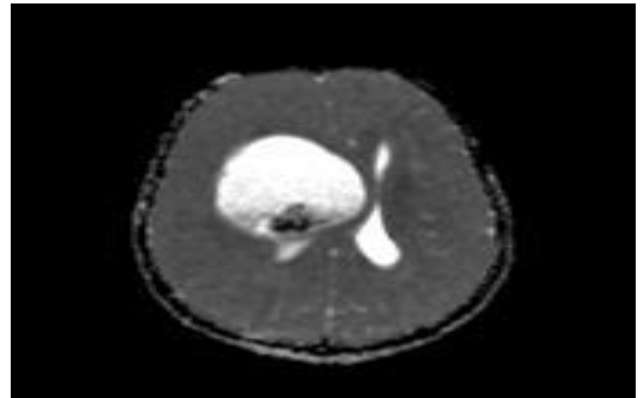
T2-weighted MRI brain (P+C), axial view showing a cystic lesion in the frontoparietal lobe causing significant compression of the right lateral ventricle.
